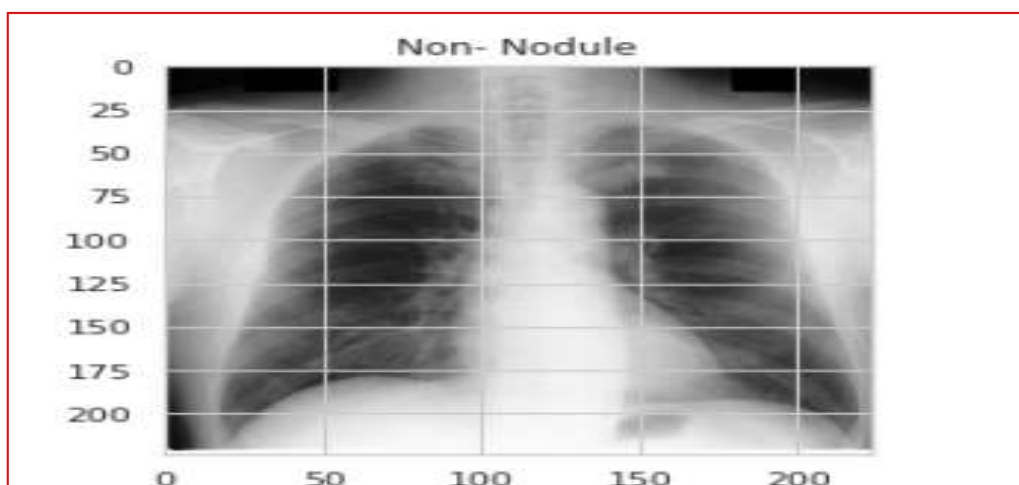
Xray Displaying Non Nodule Image with pulmonary readings
